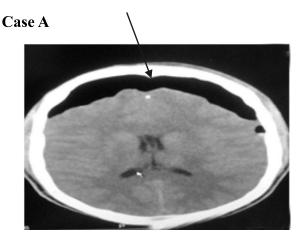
Axial brain CT at the level of lateral ventricles showing frontal intracranial, extra-axial (sub-dural) air density lesion overlying and compressing posteriorly both frontal lobes with air dipping into the interhemispheric fissure and separation of the frontal lobes to a peak like configuration (black arrow) characteristic of Mount Fuji sign of Tension pneumocephalus.
